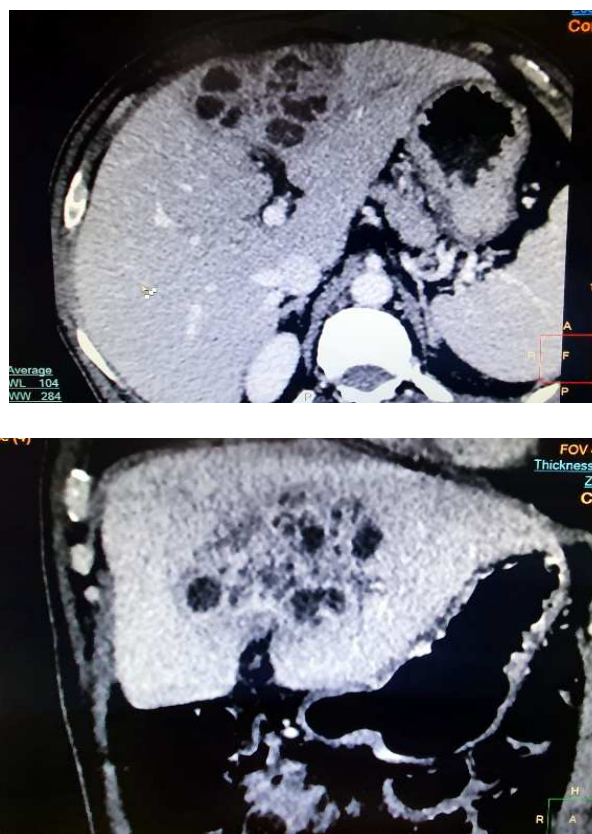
Contrast CT scan of the abdomen showed an ill-defined multiseptated low attenuated mass lesion in the left lobe of the liver with the honeycombing appearance
